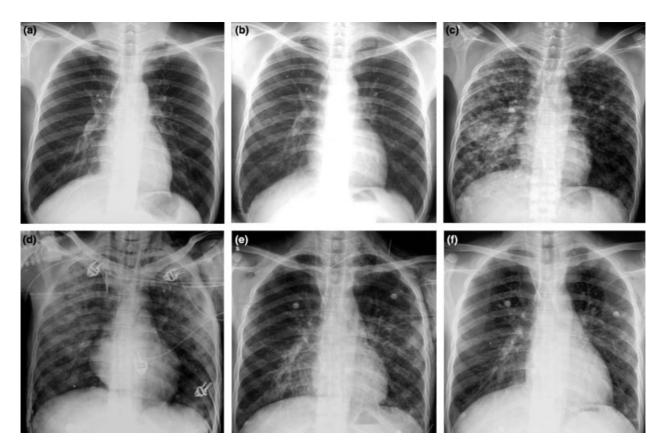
X-ray manifestations during the course of acute respiratory distress syndrome. Picture (a) was taken a month before admission; the patient visited the hospital for 2 days of fever 3 months after renal transplantation (b); three days later, X-ray suggested that severe pneumonia developed (c), and the patient was admitted to the intensive care unit, he was subjected to our rescue protocol immediately, including mechanical ventilation and continuous renal replacement therapy, (d) was taken 2 days after admission; 7 days after admission, the X-ray manifestation was significantly improved and the patient was successfully extubated (e); and (f) was taken 4 days thereafter.
